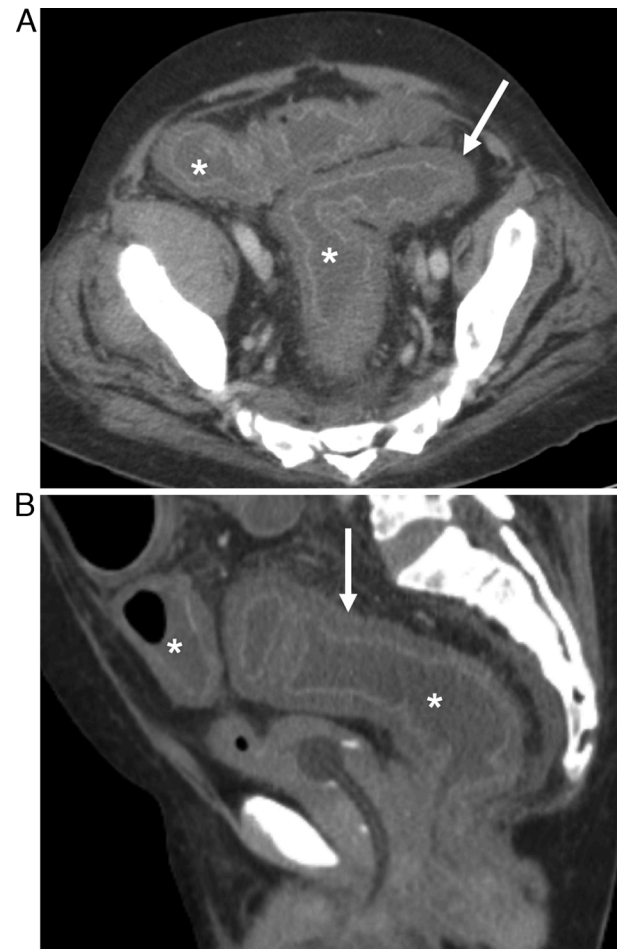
73-year-old man with COVID-19. Axial (A) and sagittal (B) IV contrast-enhanced CT images show colorectal thickening (arrows), intestinal distention of the colon (asterisks). The patients were admitted in the intensive care unit and underwent mechanical ventilation 2 days after the CT.
